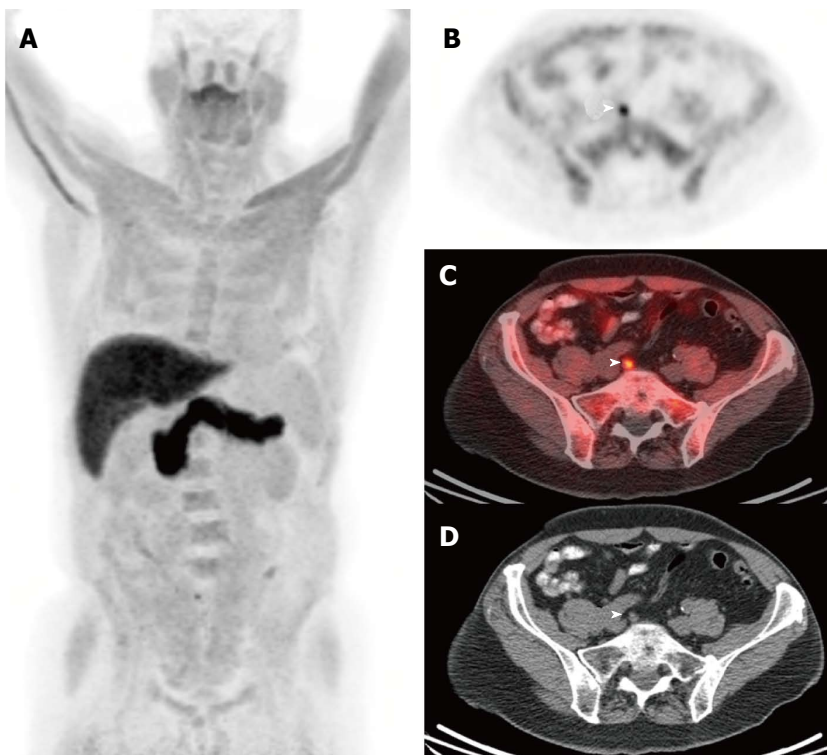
Fluciclovine. Selected images from a (^{18}F)fluciclovine-positron emission tomography/computed tomography study performed in a man who underwent prostatectomy for Gleason 8 prostate adenocarcinoma 11 years ago. He developed biochemical recurrence with a serum PSA of 0.8 ng/mL and a PSA doubling time of 14 mo at the time of the (^{18}F)fluciclovine-PET/CT study. The anterior maximum intensity projection (MIP) image (A) and the axial PET (B), fusion (C), and CT (D) images near the level of the pelvic inlet demonstrate focal activity in a subcentimeter right common iliac lymph node. This appearance is highly suspicious for a lymph node metastasis. Images courtesy of Ephraim Parent MD, PhD, and David Schuster, MD, Emory University, Department of Radiology. PET/CT: Positron emission tomography/computed tomography.
